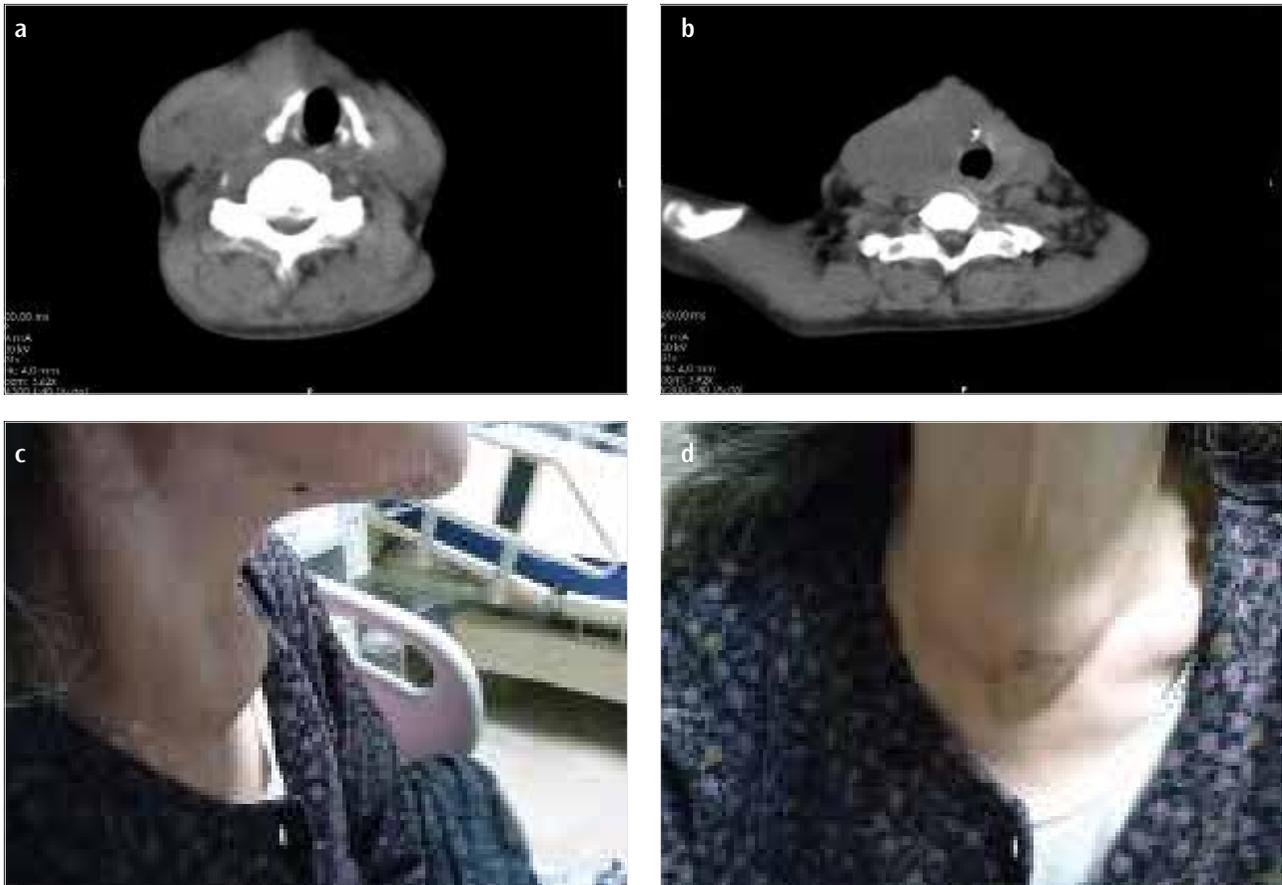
a-d. (a, b) Axial CT showing a hypodense solid mass lesion on the left thyroid lobe. (c, d) Lateral and anterior photographs of the neck showing a lump on right thyroid gland area
